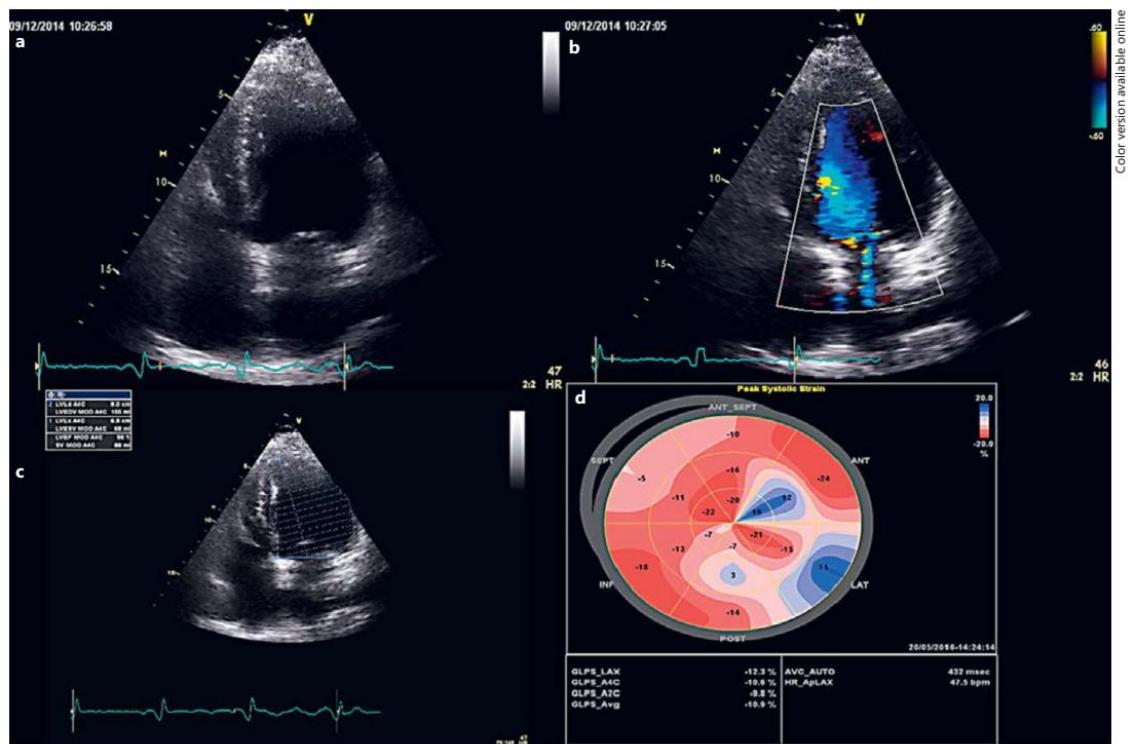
a Transthoracic echocardiogram, apical 4-chamber view, showing a reduction of the left ventricular dimension. b Mitral valve Doppler colour flow showing mitral regurgitation grade I/IV. c Left ventricular ejection fraction of 56%, calculated by biplane Simpson's method. d Bull's eye plot of peak systolic strain, with a left ventricular circumferential strain rate of -12.3% and a longitudinal strain rate of -10.9%.
